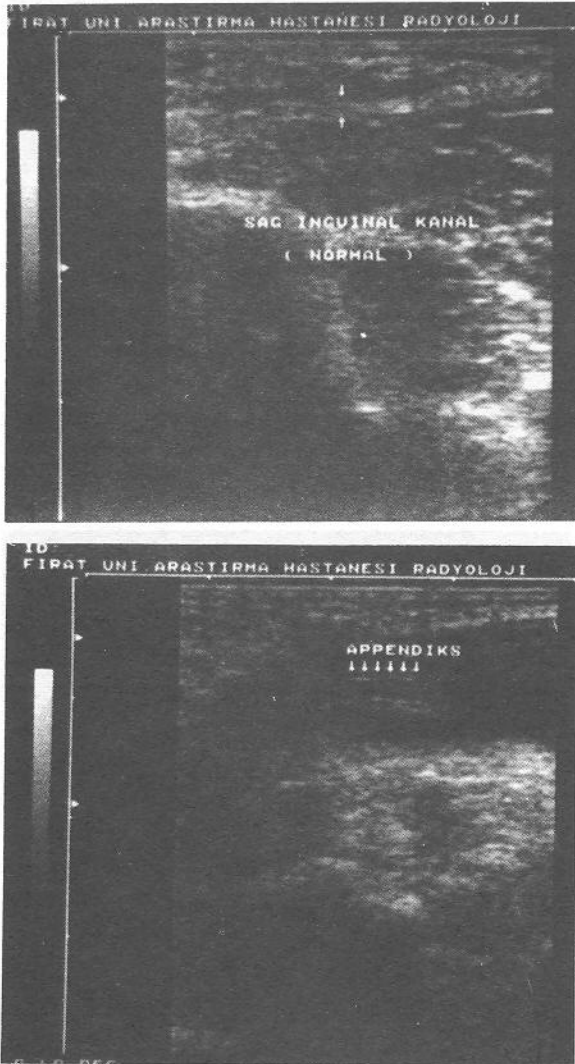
Ultrasonographic view of inguinal region. A) Normal groin. B) A sliding appendiceal inguinal hernia on the right groin.
